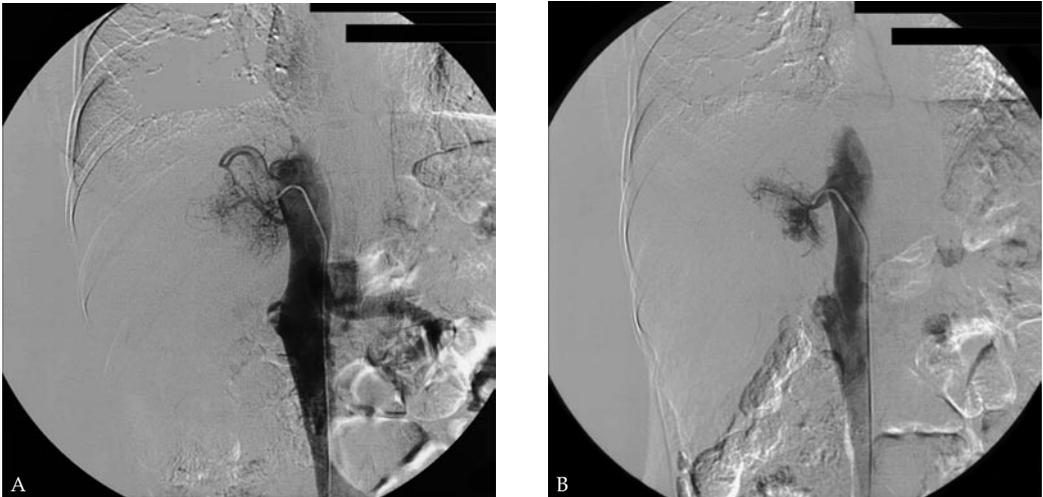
Selective hepatic vein injection showed a part consistent with hepatic vein confluence and a tangle of vessels in the area of hepatic veins (A) and a small vein that had been seen during Doppler examination (B).
